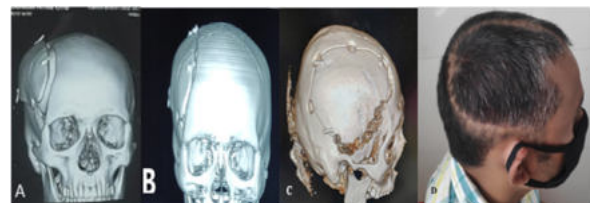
(A) CT with 3D reconstruction (POD 2) showing elevation of the bone flap due to raised ICP. (B) POD 7, the bone flap has been placed in position after the ICP has reduced. (C) & (D) showing patient on follow up after 3 month we can see that the bone flap has been fused and the patient has minimal deformity of the skull.
